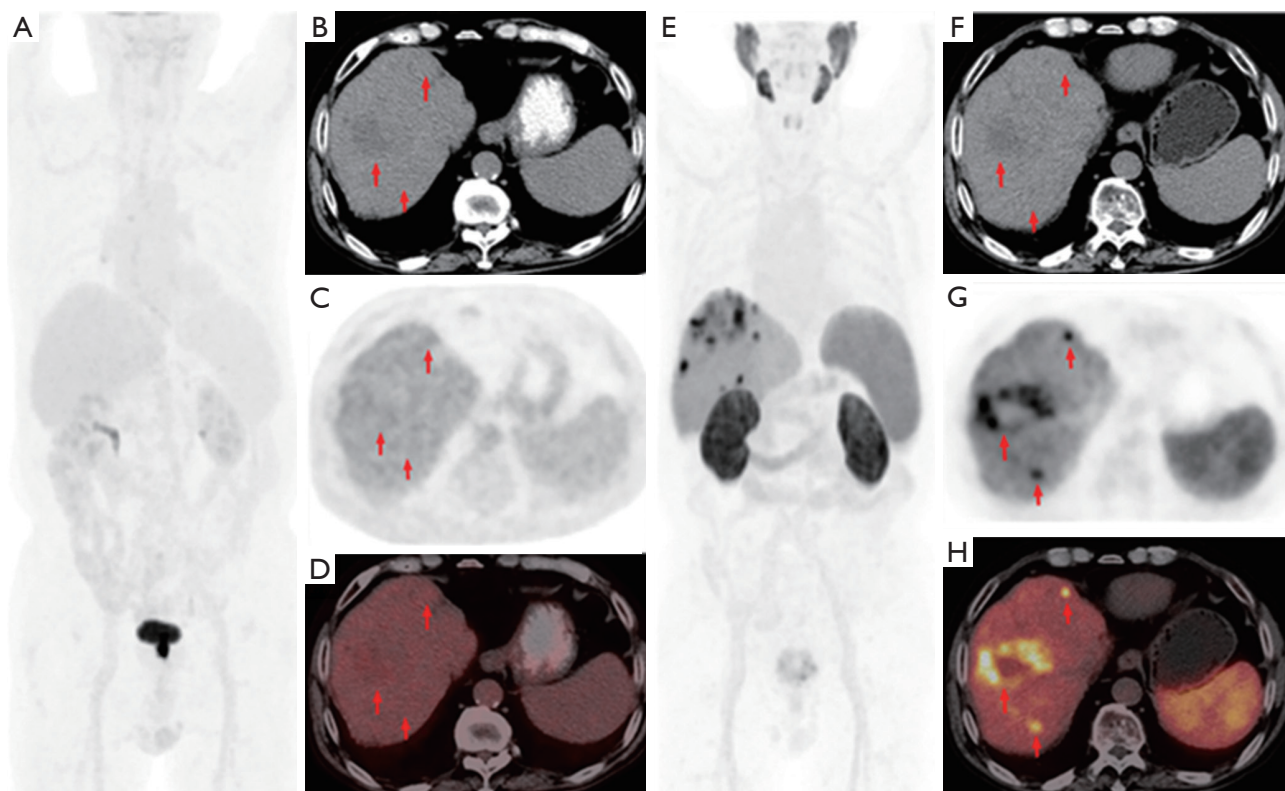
The MIP of ^{18}F -FDG PET-CT (A) and ^{18}F -PSMA-1007 PET-CT (E). The plain CT image (B), PET image (C), and ^{18}F -FDG PET-CT fusion image (D) showed multiple round and slightly low-density foci in the liver (red arrows). The SUVmax of the largest lesion located in the S8 segment with a size of 4.19×4.37 cm was 3.3, similar to that of the surrounding normal liver tissue. The plain CT image (F), PET image (G), and ^{18}F -PSMA-1007 PET-CT fusion image (H) showed abnormal radioactive uptake at the corresponding site with a SUVmax of 25.6 (red arrows). MIP, maximum intensity projection; ^{18}F -FDG, ^{18}F -fluorodeoxyglucose; PET-CT, positron emission tomography-computed tomography; PSMA, prostate-specific membrane antigen; SUVmax, maximum standardized uptake value.
